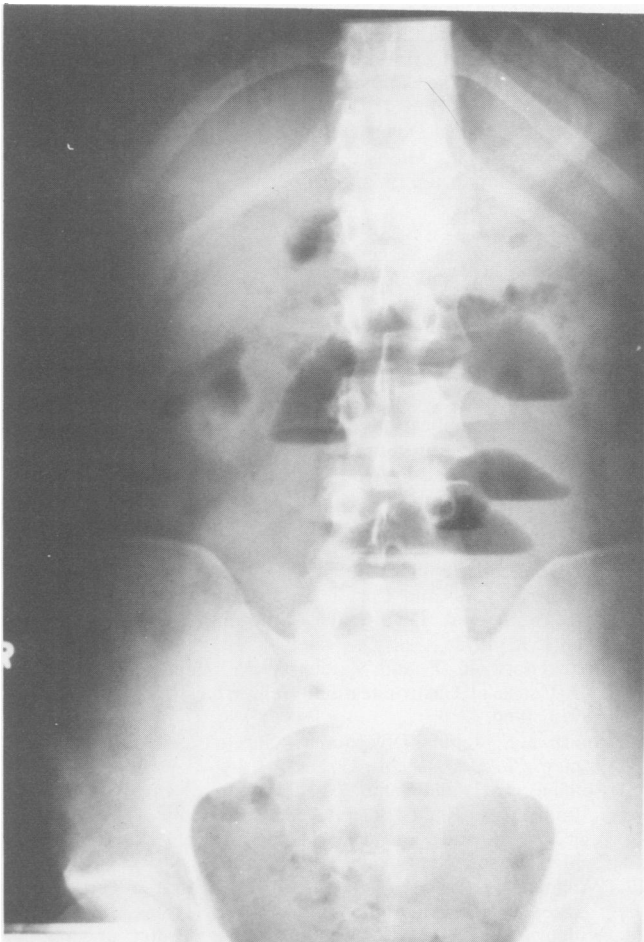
Case 6. Erect abdominal x-ray showing numerous air-fluid levels and dilated small bowel.
